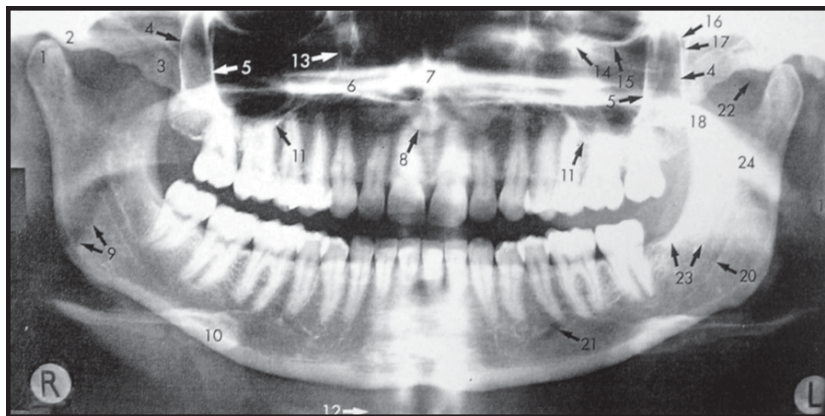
OPG radiographic view with anatomical landmarks outlined. It is a radiographic technique for producing a single image of the facial structures that includes both the maxillary and mandibular dental arches and their supporting structures. Various structures visible are:
